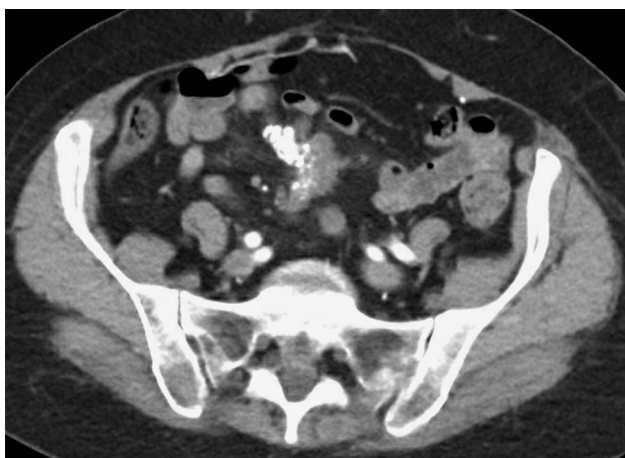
Computed tomography of the abdomen and pelvis with contrast showed a 3.3-cm calcified mass in the mesentery suspicious for neuroendocrine tumor.
